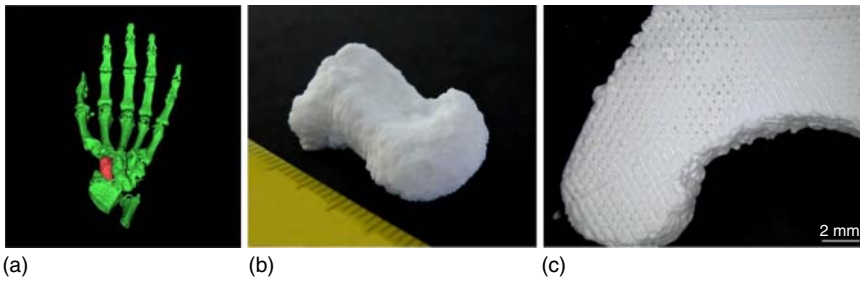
CT data extraction and translation to a STL file (a) to design and additively fabricate a human scaphoid bone from pasty CPC in actual physiological dimensions (b) after using open source software. Fabrication via layer-by-layer strand deposition, bar = 2 mm (c) [74].
